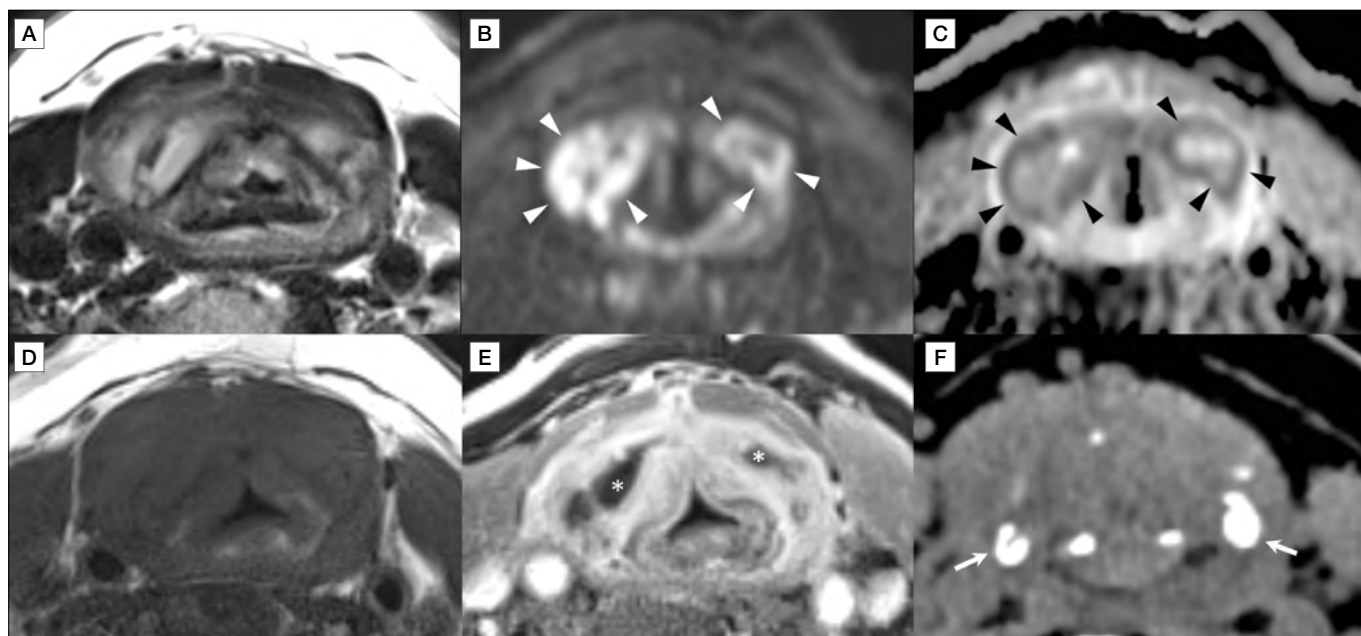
Extensive post- CO_2 TOLMS thyroid chondritis in patient No. 2. Different axial sequences at the level of the false vocal cords: T2-weighted (A), DWI b900 (B), ADC map (C), T1-weighted (D) and contrast-enhanced fat-saturated T1 (VIBE) (E), and soft-tissues window axial CT reconstruction at the glottic level (F). Swollen appearance and extensive full thickness signal changes of both thyroid laminae with very hyperintense T2-weighted and isointense T1-weighted signal, peripheral areas with diffusion restriction pattern, as demonstrated by high signal on DWI b900 and corresponding low signal on ADC map (arrowheads in B and C; mean ADC values of $1.05 \times 10^{-3} \text{ mm}^2/\text{s}$), and intense peripheral contrast enhancement with central avascular areas (asterisks in E). Consequent reduction of the airway. On CT, there is extensive erosion of both thyroid laminae and only its most posterior segments are visible (arrows in F).
